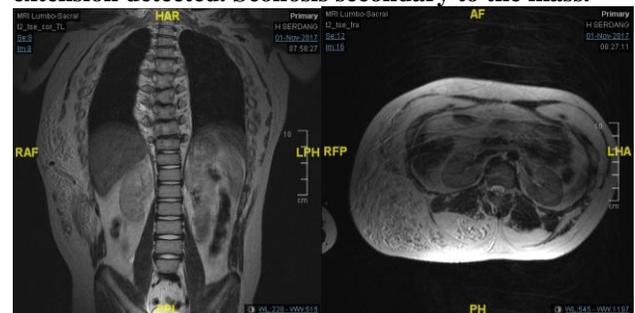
Contrast-enhanced Magnetic resonance imaging (MRI) scan of thorax-abdomen-pelvis, showing large mass at the right posterolateral aspect of the thoraco-abdominal wall containing extensive slow flow vascular channels suggestive of a slow-flow vascular malformation. Intra thoracic and intraspinal extension (T7-T9 level) of the mass with no obvious myelopathy. Possible verrucous hemangioma.
